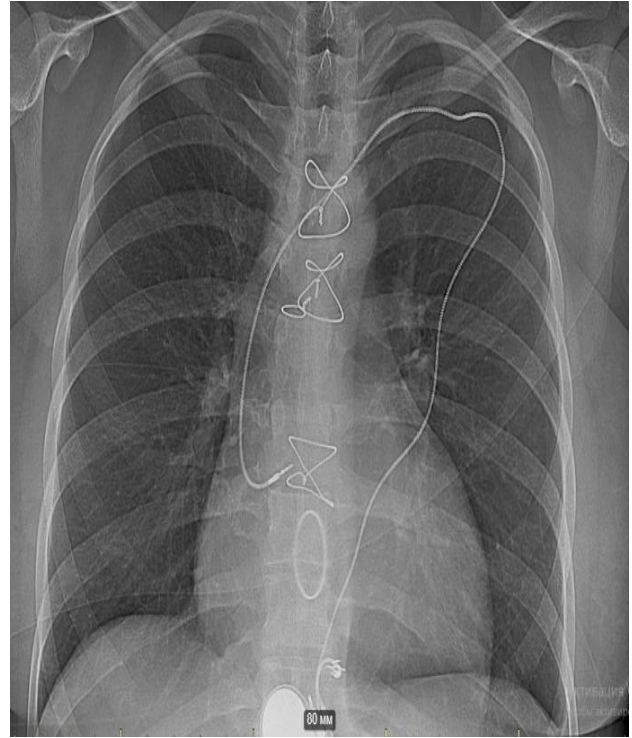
Patients X-ray after the operation.
